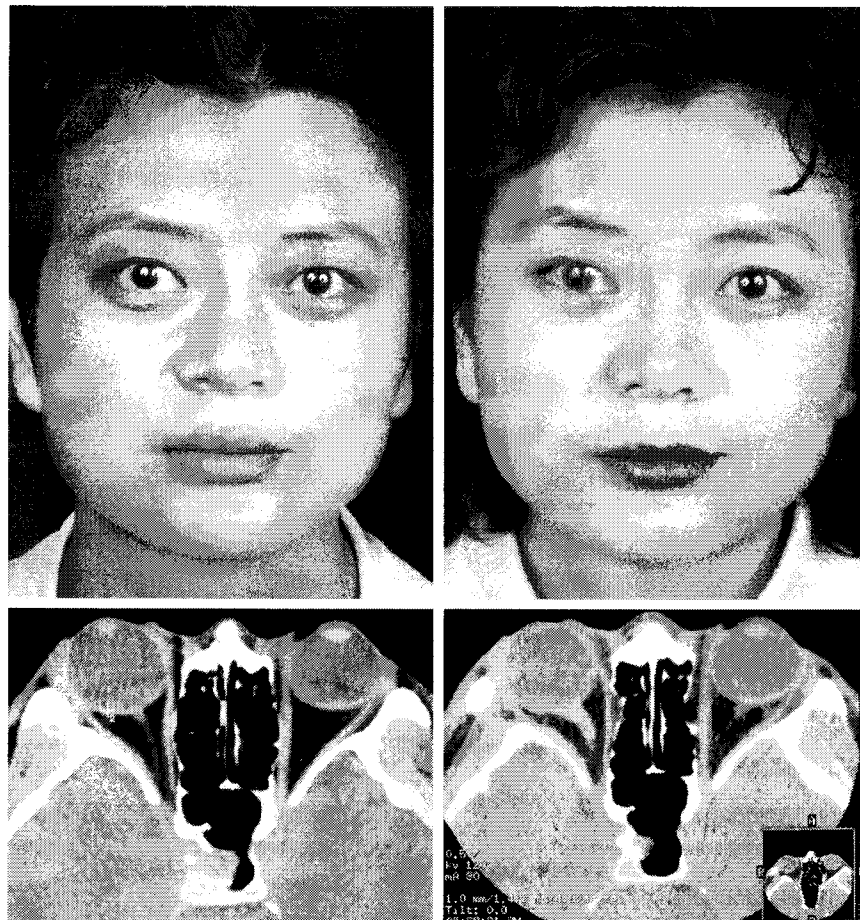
Case 1. (Above, left) Preoperative view of a 38-year-old woman with nonsyndromic exorbitism and high myopia of the right eye. (Above, right) Postoperative view 1 year after two-wall expansion of the right orbit, burring of the orbital rim, and medial wall expansion of the left orbit. No bone graft was required for this mild unilateral proptosis, but bone grafting would have been necessary in a case of associated Graves' ophthalmopathy. (Below, left) Preoperative computed tomography scan. (Below, right) Postoperative scan.
